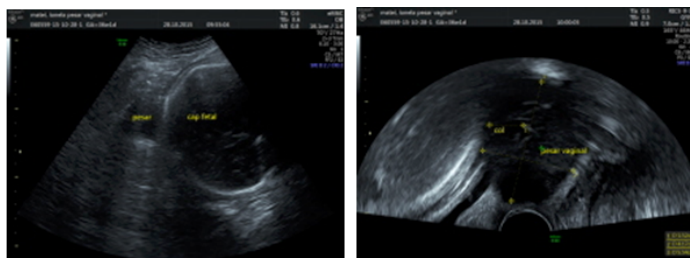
Ultrasonographic aspect of a vaginal cerclage pessary - note the relation between the device and the internal orifice of the cervix
